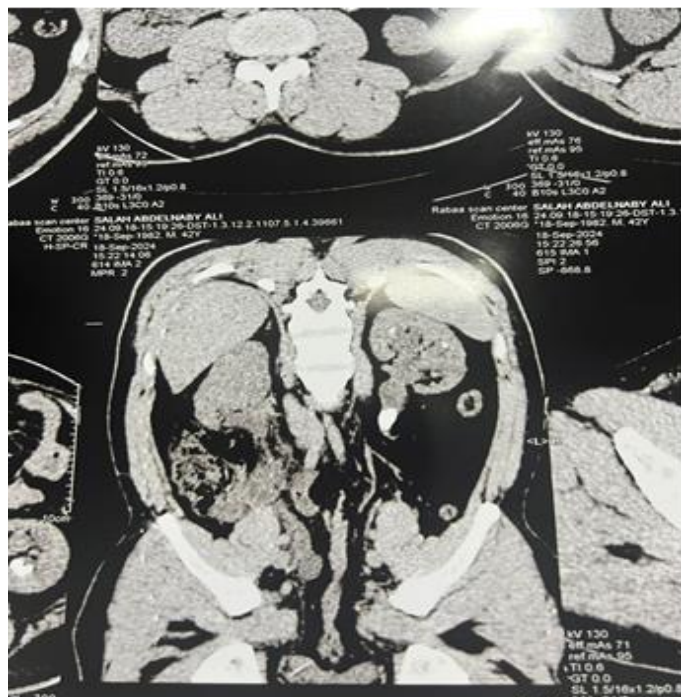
Non contrast CT showed right lower ureteric stone and left upper ureteric large stone and multiple sizable left renal stones.
